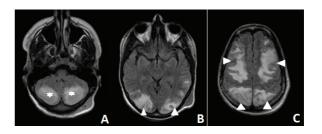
Posterior Reversible Encephalopathy Syndrome Brain magnetic resonance images of FLAIR (fluid attenuated inversion recovery) sequence showing bilateral and symmetrical increased intensity at cerebellar (asterisks) (A) and posterior temporal and occipital (B), and parietal and frontal lobes (arrowheads) (C). Cases typically involve occipital and parietal regions.
